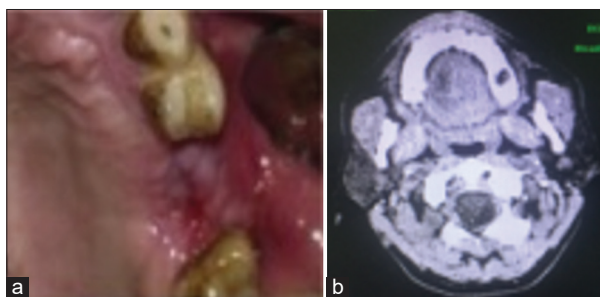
(a) Intraoral image with unhealed socket of tooth 26, (b) Computed tomography scan showing an opacity and a discontinuity in the floor of the maxillary sinus measuring 7 mm (Case 8)
